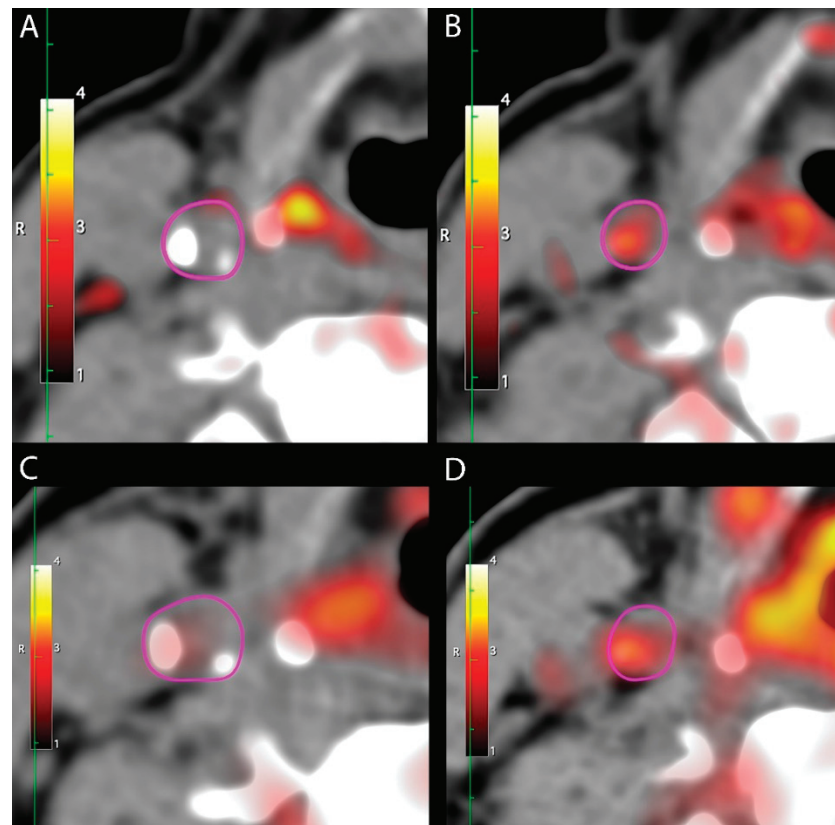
PET/CT images at baseline with high and low uptake of $[^{64}\text{Cu}]\text{DOTATATE}$. Representative baseline axial images showing the carotid artery outlined in pink. (A) An axial slice with calcifications and low uptake of $[^{64}\text{Cu}]\text{DOTATATE}$ ($\text{SUV}_{\text{mean}} = 0.9$). (B) An axial slice with minimal calcifications and high uptake of $[^{64}\text{Cu}]\text{DOTATATE}$ ($\text{SUV}_{\text{mean}} = 1.4$). (C,D) $[^{18}\text{F}]\text{FDG}$ uptake in the same locations for comparison.
